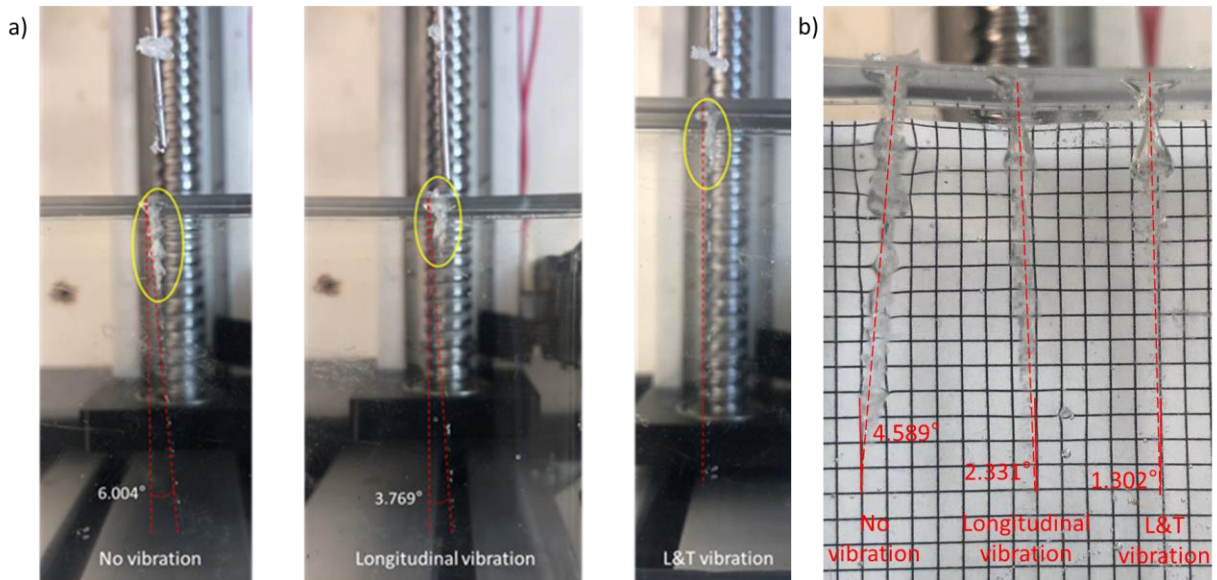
Insertion experiments with and without ultrasonic vibrations.
